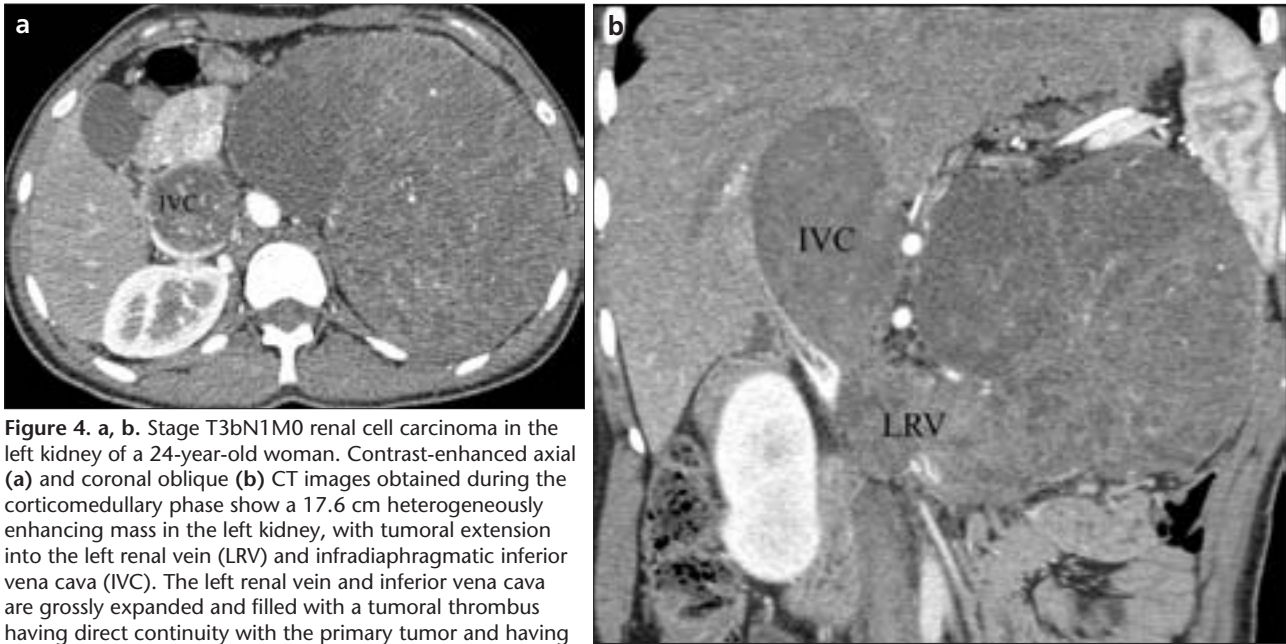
a, b. Stage T3bN1M0 renal cell carcinoma in the left kidney of a 24-year-old woman. Contrast-enhanced axial (a) and coronal oblique (b) CT images obtained during the corticomedullary phase show a 17.6 cm heterogeneously enhancing mass in the left kidney, with tumoral extension into the left renal vein (LRV) and infradiaphragmatic inferior vena cava (IVC). The left renal vein and inferior vena cava are grossly expanded and filled with a tumoral thrombus having direct continuity with the primary tumor and having heterogeneous enhancement.
